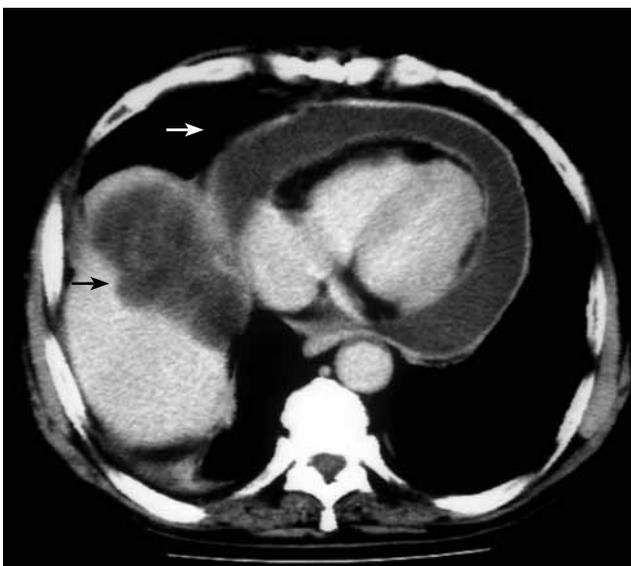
Computed tomography image showing the thickened pericardium with pericardial effusion (white arrow) and the regularly contoured lesion in the right hepatic lobe (black arrow).
